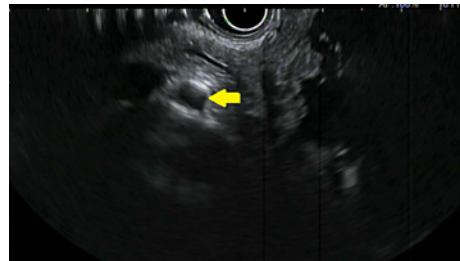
Upper gastrointestinal ultrasound showing a lesion in the perigastric region suggestive of a cyst (yellow arrow).
